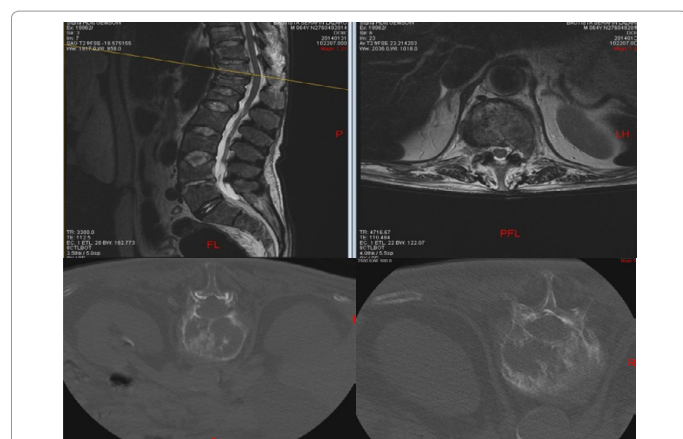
Simple MRI. Sagittal and Axial views. Diffuse infiltration of multiple vertebrae with discrete hypointense T1, discrete hyperintense T2 and no T2 Fat-sat enhancement, related to tumoral etiology. T9 to L1 vertebral collapse that conditions thoracolumbar xifosis. CT-guided biopsy reported multiple myeloma.
